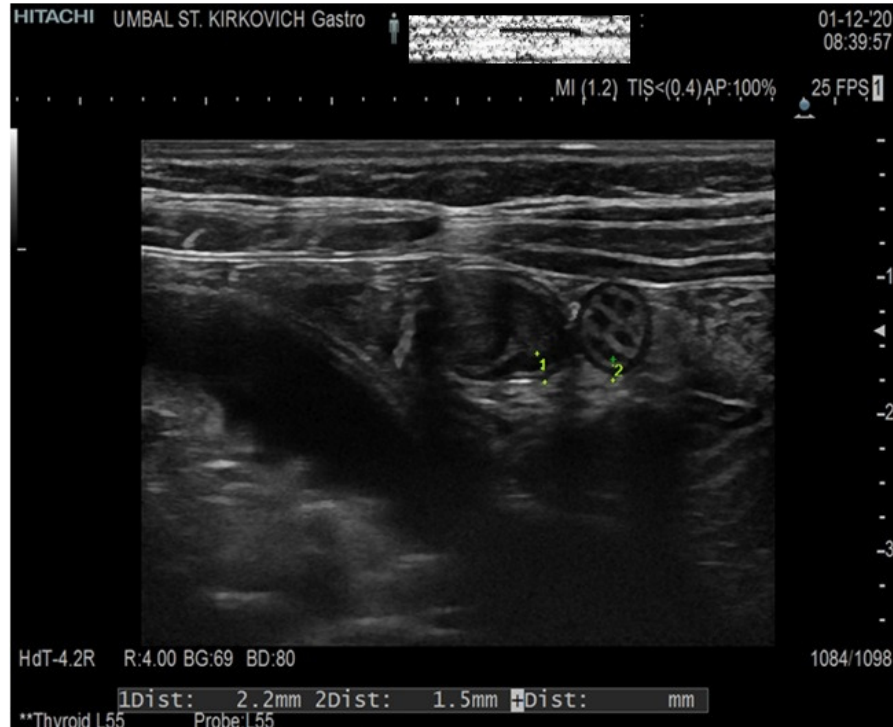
Abdominal ultrasound of patient number three.
